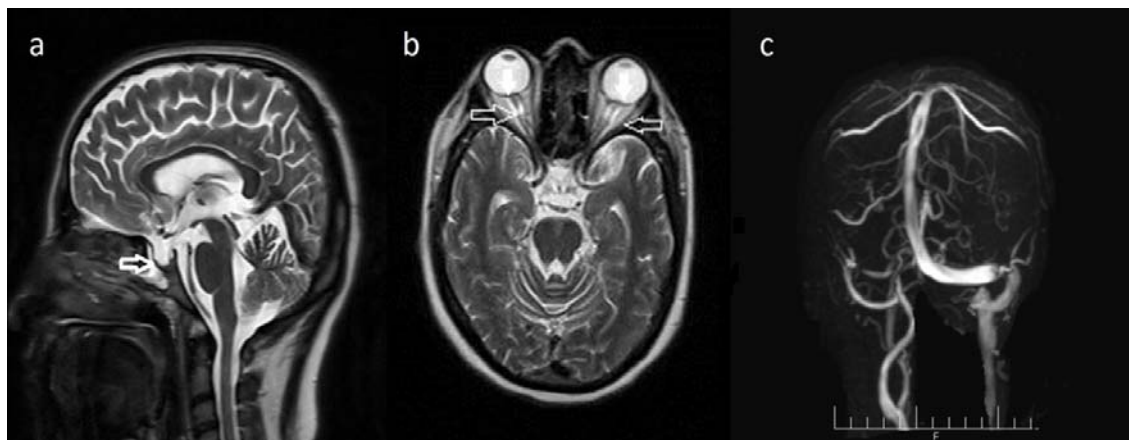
Cranial magnetic resonance imaging (MRI) of the patient. (a) Sagittal T2-weighted image through the midline shows a partial empty sella (arrow). (b) Axial T2-weighted image through the level of optic nerves shows prominent subarachnoid space (arrows), and protrusions of optic nerve heads (white arrow) suggestive of papilledema. (c) Magnetic resonance venography (MRV) without contrast shows smooth-bordered stenosis in distal portions of both transverse sinuses (arrow).
